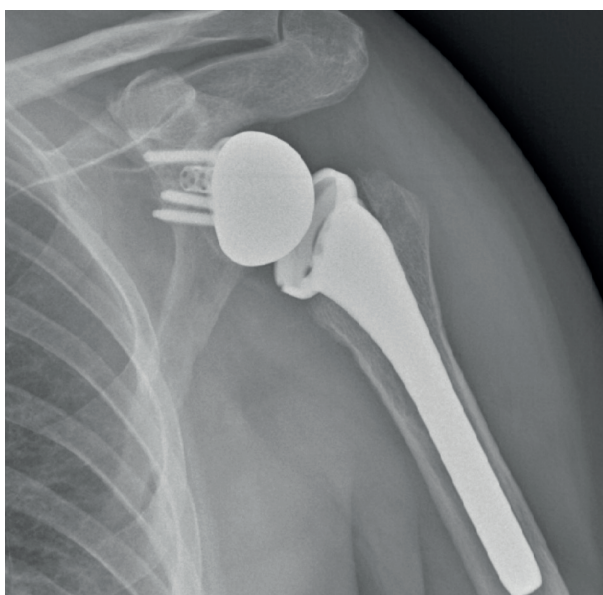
Post-operative x-rays examination after revision surgery
